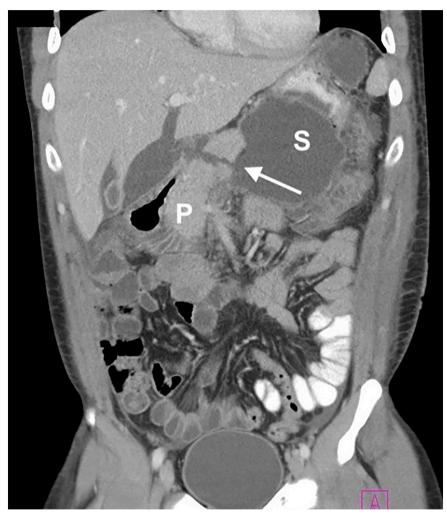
Abdominal CT scan (coronal) showing complete transection of the pancreas (arrow) and peripancreatic fluid collections (P-pancreas, S-stomach).
